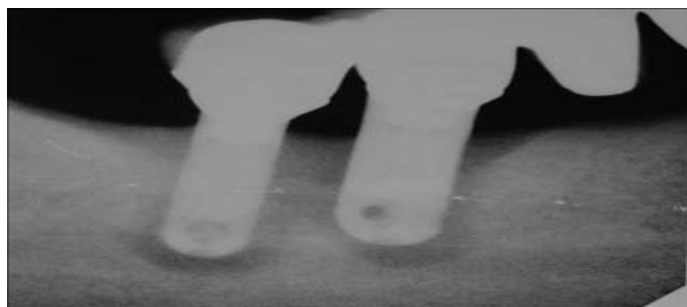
Radiograph in 2002 demonstrating deosseointegration of both implants supporting the TISP. The patient had parafunctional habits.
